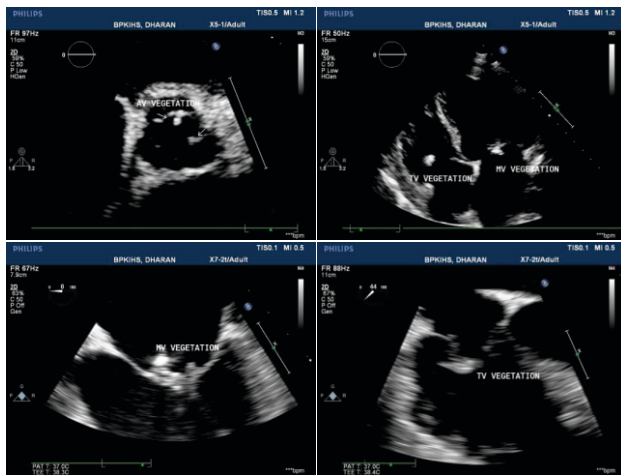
Upper images: Transthoracic echocardiography showing vegetations on aortic valve (parasternal short axis view), tricuspid, and mitral valve (apical 4-chamber view). Lower images: Transoesophageal echocardiography showing vegetations on mitral and tricuspid valves.
